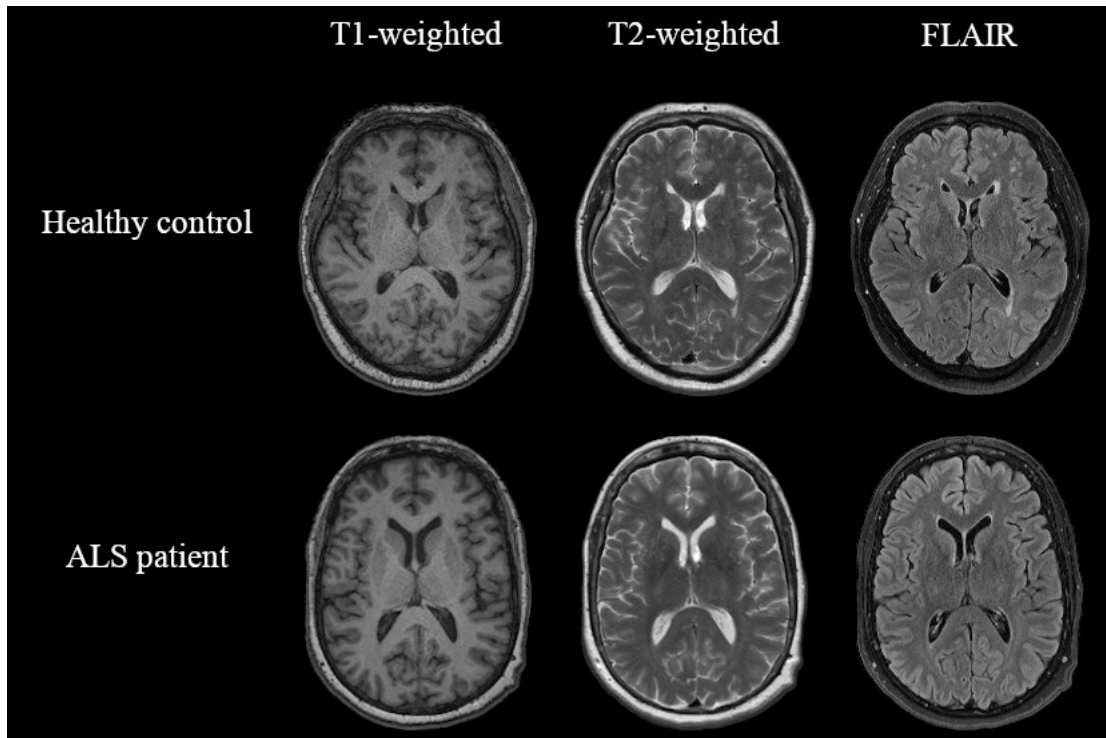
MRI scans of a healthy control and an ALS patient. No obvious structural differences are present between the images of these two subjects, making diagnosing ALS with clinical MRI assessment impossible. FLAIR = fluid-attenuated inversion recovery
